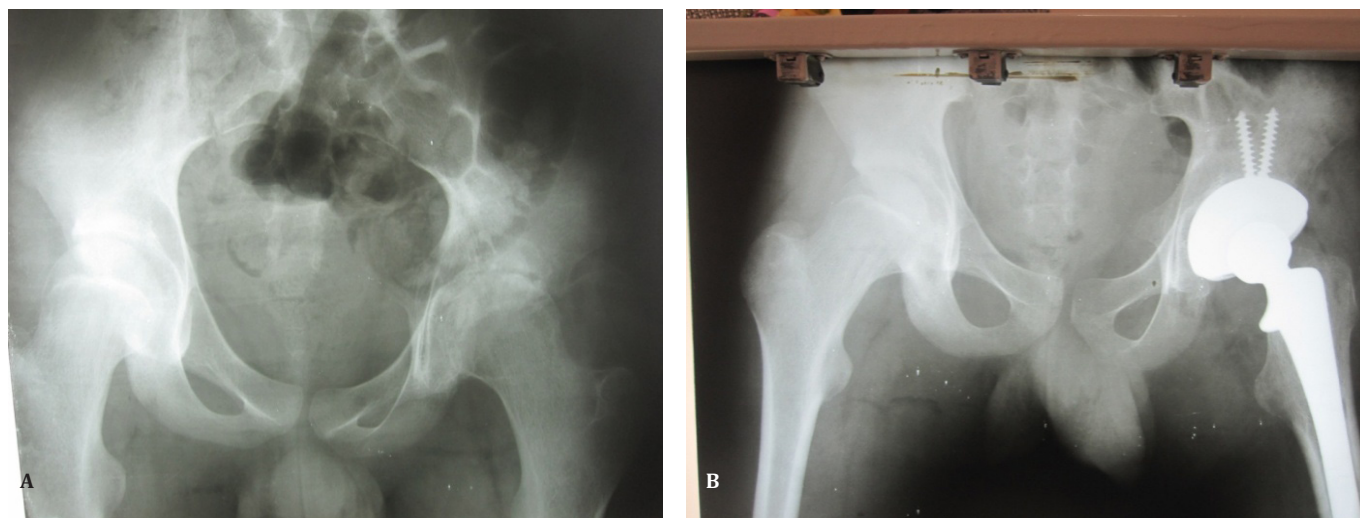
(A) Preoperative anteroposterior (AP) radiograph showing ankylosed hip on the left side. (B) Post-operative X-ray, one year follow-up.
